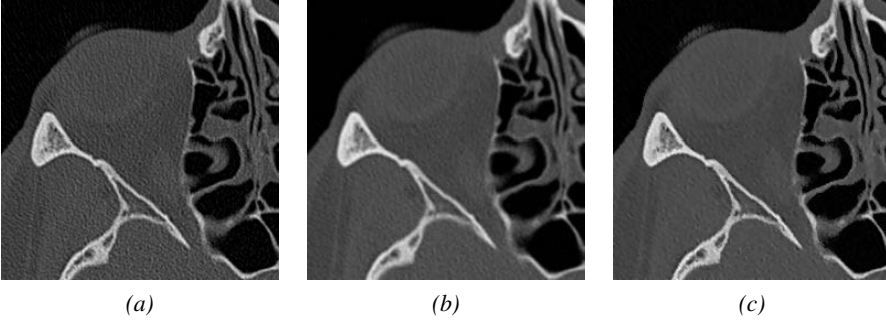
Noise reduction: (a) original noisy CT image of the thin bone structures in the orbit; (b) Gaussian smoothing; (c) edge-preserving bilateral smoothing.
